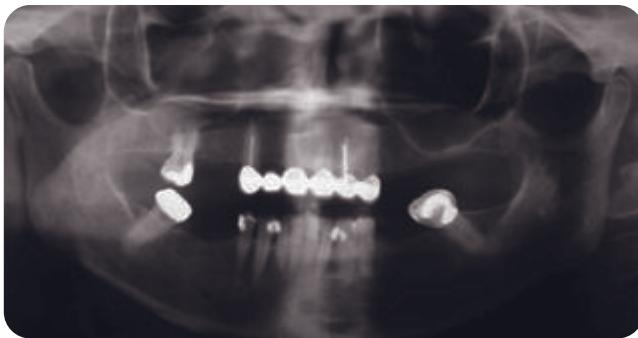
Pretreatment panoramic radiograph suggesting endodontic concerns and several deep restorations. Bone levels are acceptable and there is no significant mobility.
